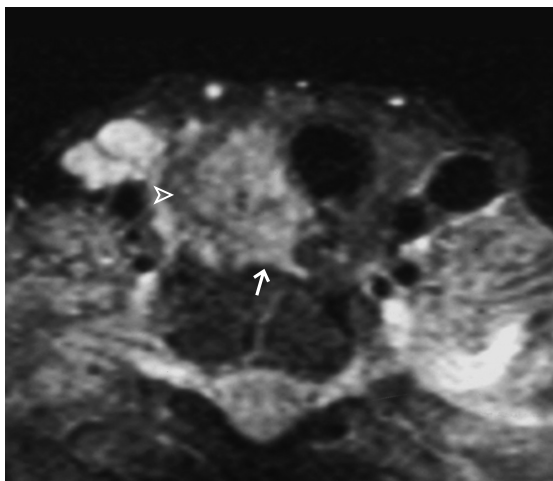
Axial T2WFS MRI (same patient as above) shows that the lesion is intermediate in T2 signal (Δ). Note the extrathyroidal extension (\rightarrow) posteriorly. Excision confirmed papillary carcinoma.
